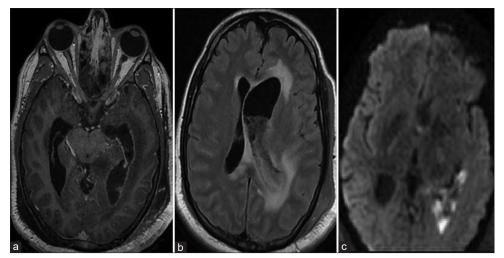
(a) Gadolinium-enhanced magnetic resonance imaging showed thickened ependymal sheath enhancement with increasing ventricular size. (b) In fluid-attenuated inversion recovery, the ventricle contains a layering of fluid and sediment, suggesting collection. (c) There was diffusion restriction in the posterior temporal horn of the lateral ventricle.
